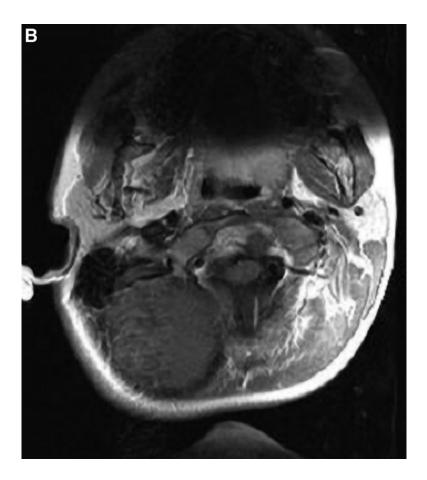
Radiographic findings from Patient 1. (A) Three-dimensional reconstructed computed tomography image demonstrates laminar fusion at C2–3 vertebrae (posterolateral aspect of cervical spines). (B) Cervical spine magnetic resonance image shows a partially enhancing lesion anterior to the atlas and axis. The confirmative diagnosis of this lesion is not yet known.
